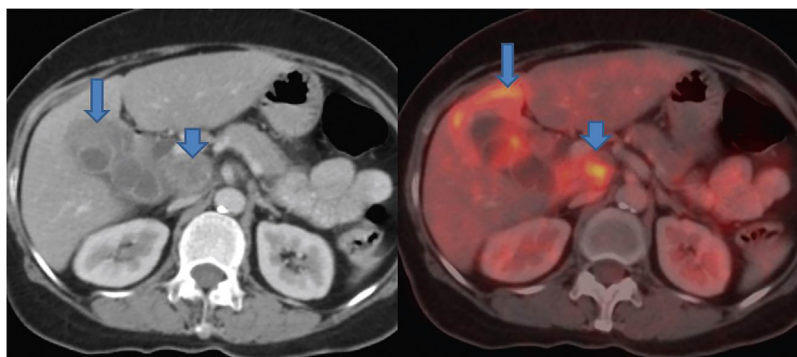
PET-CT shows asymmetrical mural thickening of the GB (arrow). There is adjacent liver infiltration showing FDG avidity (arrow). A large necrotic FDG avid periportal lymph node is also seen (short arrow).
